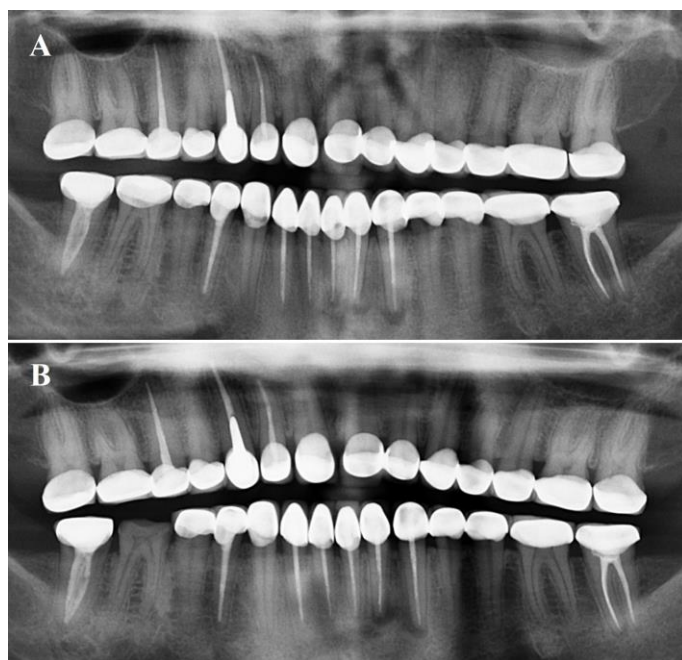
1-year (A) and 2-year (B) follow-up panoramic radiography.
